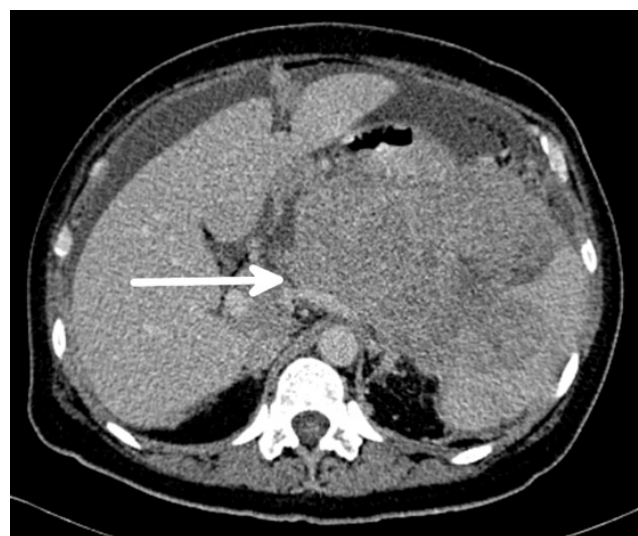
Axial view of contrast-enhanced computed tomography of pancreatic protocol; the white arrow represents the location of the tumor on the scan.
